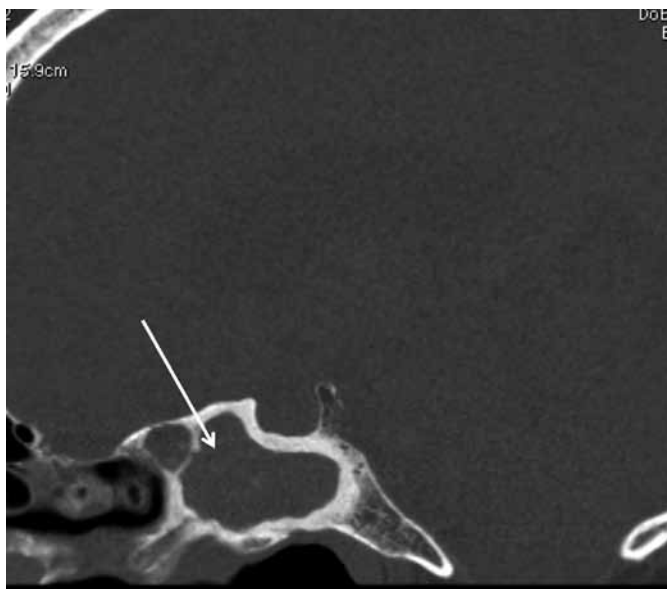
Sagittal CT image of sphenoid sinus demonstrating opacification and bone sclerosis (arrow).
